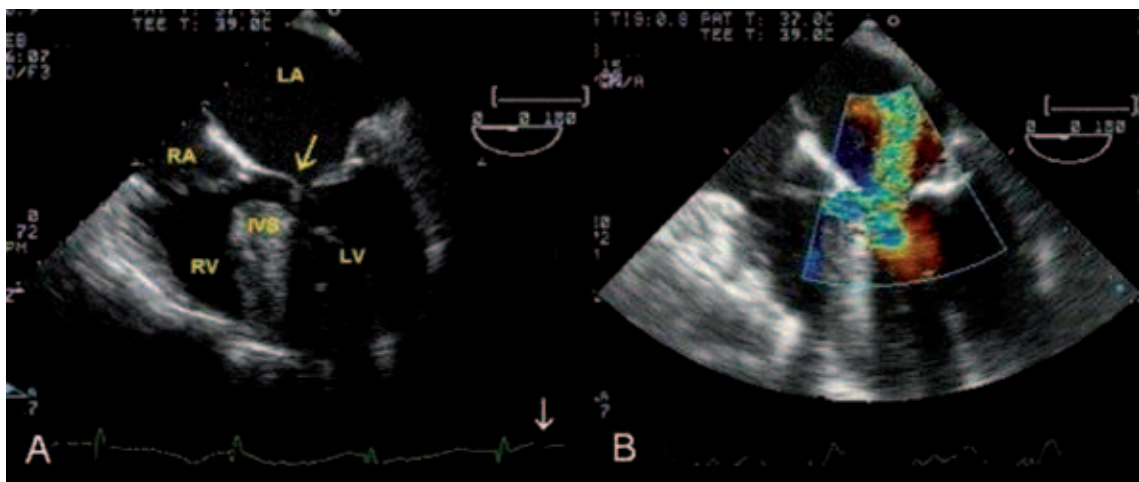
Preoperative transesophageal echocardiography images. (Midesophageal four chamber view).
